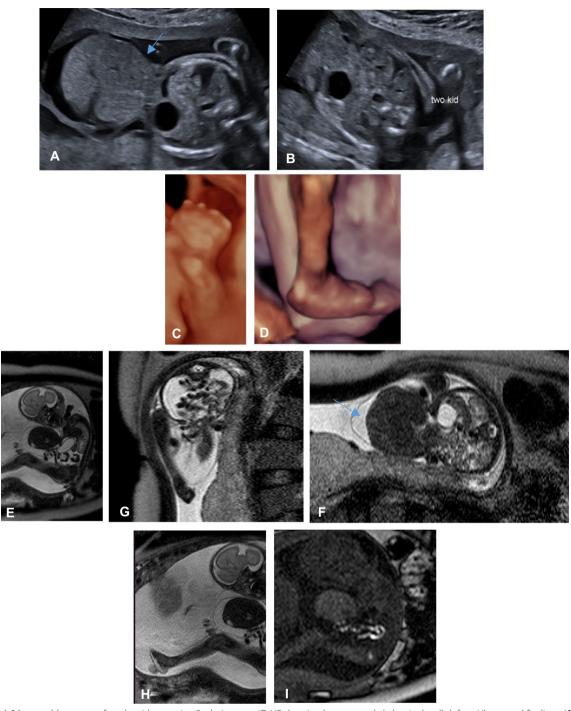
A 26-year-old pregnant female with a routine 2nd trimester 4D US showing large ventral abdominal wall defect. Ultrasound findings (A), B axial sections of the fetal abdomen show a large central abdominal wall defect with herniation of the right hepatic lobe and bowel loops through. C, D sagittal 4D images revealing clenched hands and rocker bottom feet deformity. MRI findings: E, H sagittal T2WIs showing herniated liver and small bowel loops with an overlying thin membrane and associated rocker bottom feet. F, G axial T2WIs showing the size of the hernia defect, content as well as clenched hand. I sagittal T1WIs showing meconium signals within herniated bowel distal ileal loops. Diagnosis: The combination of skeletal anomalies with large Omphalocele suggested underlying chromosomal abnormality and trisomy 18 was diagnosed by postnatal chromosomal analysis. Termination by C.S. at 37 weeks
